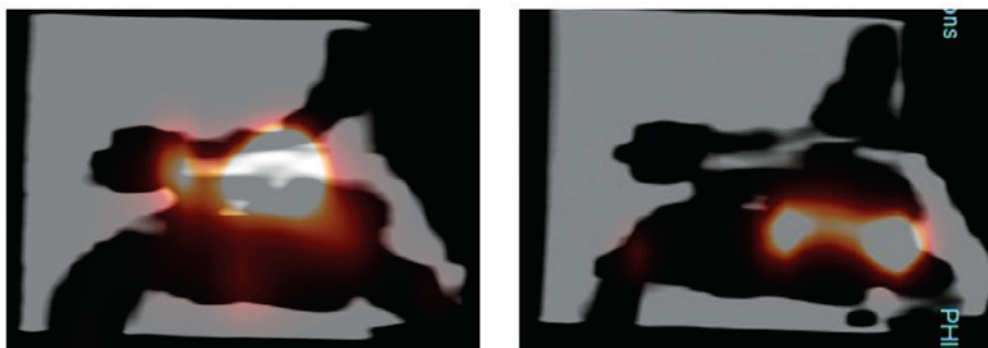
Deposition in the nasal cast model using SPECT with unit dose powder (left image) and nasal spray pump (right image).
